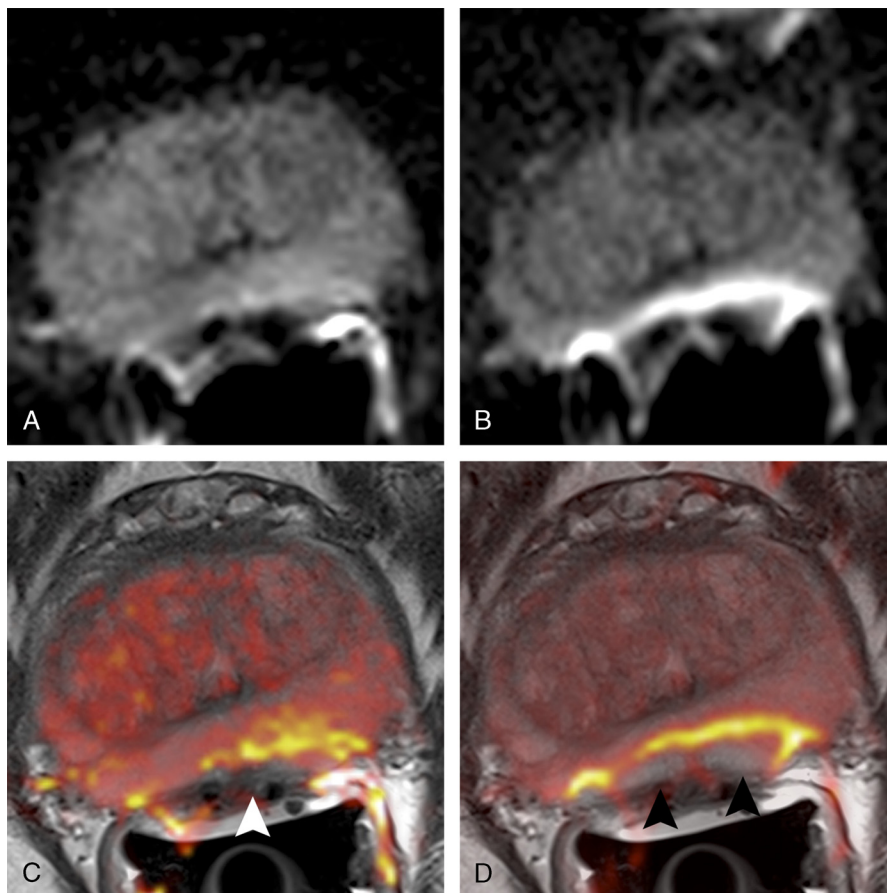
A 58-year-old male patient undergoing mpMRI of the prostate. Rs-DWI b-1000 image (A), reduced-FOV sTX-DWI b-1000 image (B), TSE-T2w image fused with rs-DWI b-1000 image (C), and with reduced-FOV sTX-DWI b-1000 image (D) at the level of the midgland are shown. The geometric distortion at the posterior aspect of the prostate close to the rectum-prostate border (arrowheads) is more pronounced on sTX-DWI (images B and D) than on rs-DWI (images A and C). Figure 2 can be viewed online in color at www.investigativeradiology.com.
